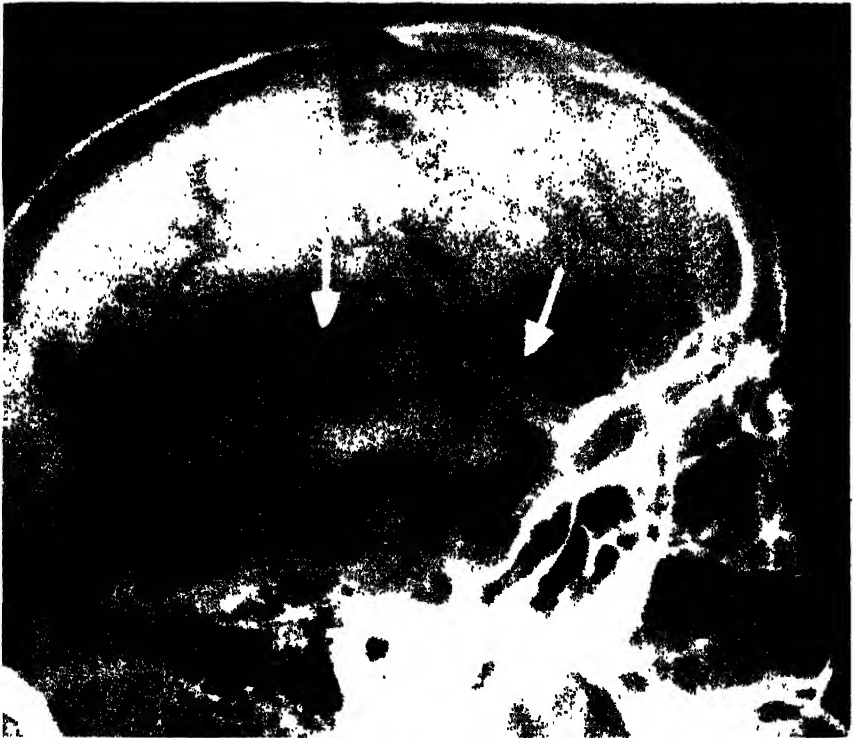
Radiograph showing a linear fracture of the skull.
